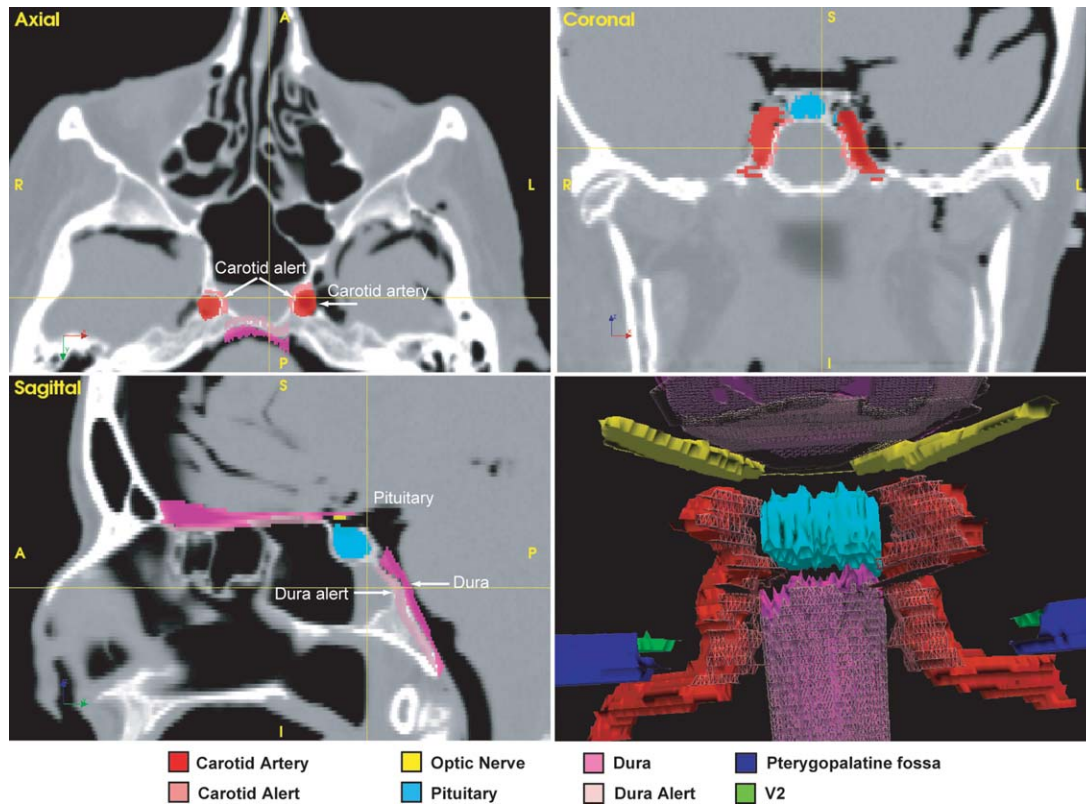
Manual segmentation of cross-sectional computed tomographic scan images was used to create a three-dimensional virtual view of anatomical structures. A = anterior; I = inferior; L = left; P = posterior; R = right; S = superior.
